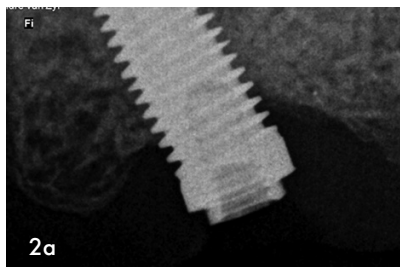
Radiograph showing broken off screw deep in implant
